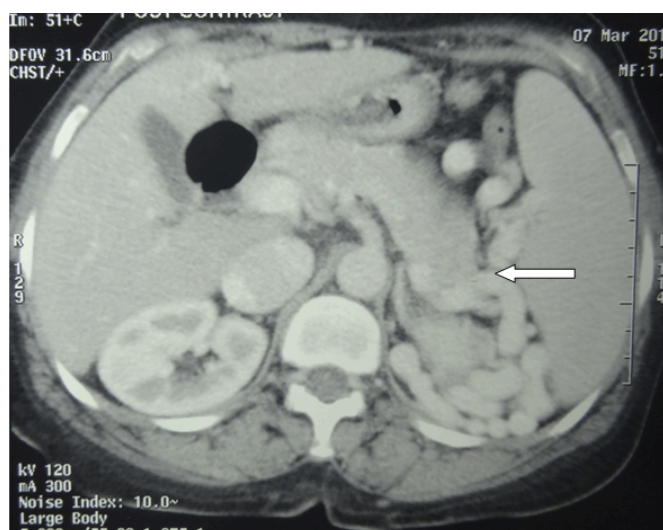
Contrast-enhanced computed tomography showing gross splenorenal collaterals (arrow).
